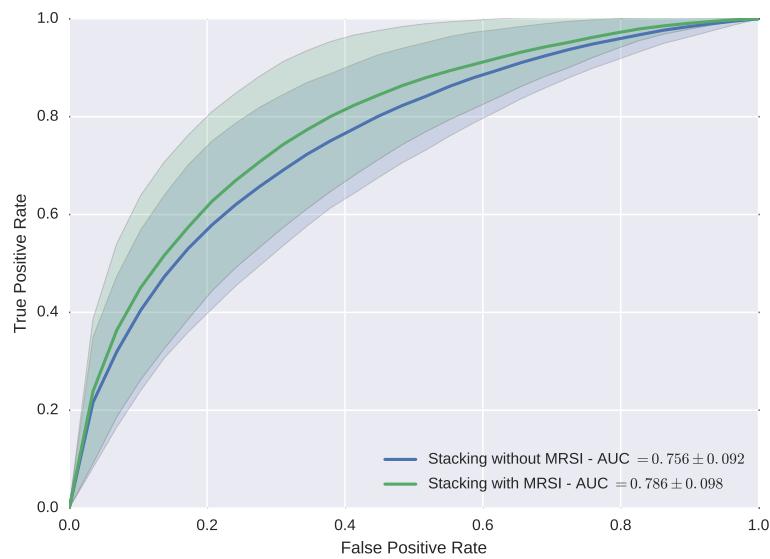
Individual patient AUC for the best configuration of the mp-MRI CAD.
